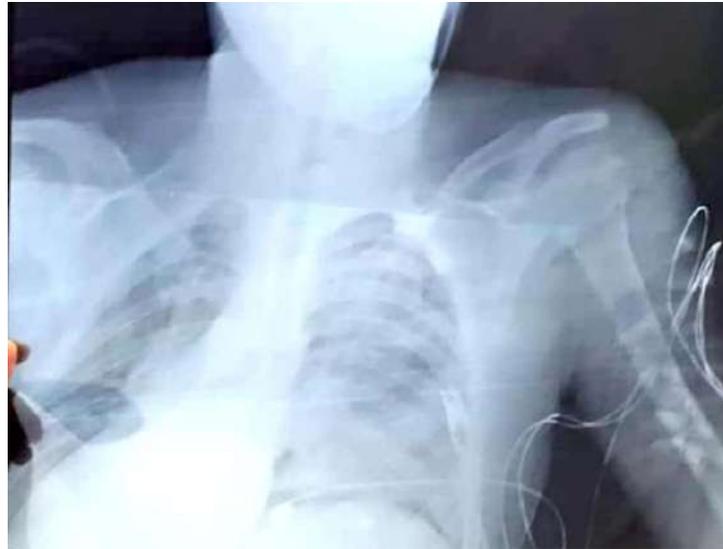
X-ray Clavicle Fracture.
